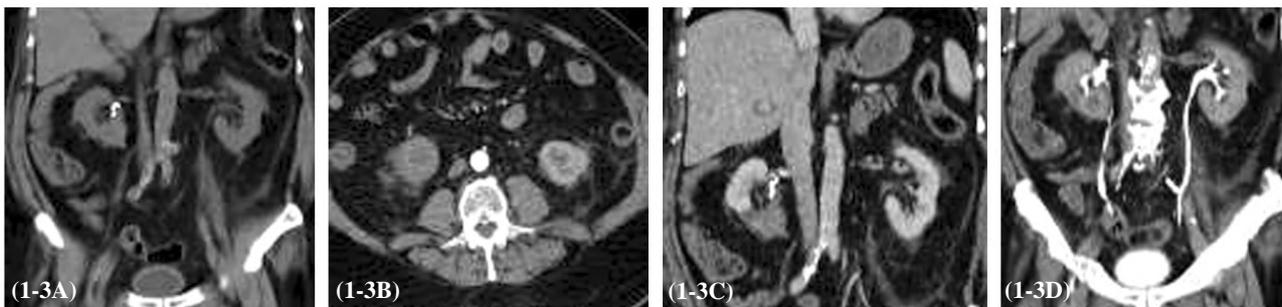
(A) Coronal Non enhanced CT images, (B, C, D) Post contrast CT axial arterial phase, coronal venous phase and coronal excretory phase respectively shows right renal lower polar mass show little enhancement with stranding and thickening perinephric fat and small perinephric hematoma, two micro coils at right renal pelvic region.
